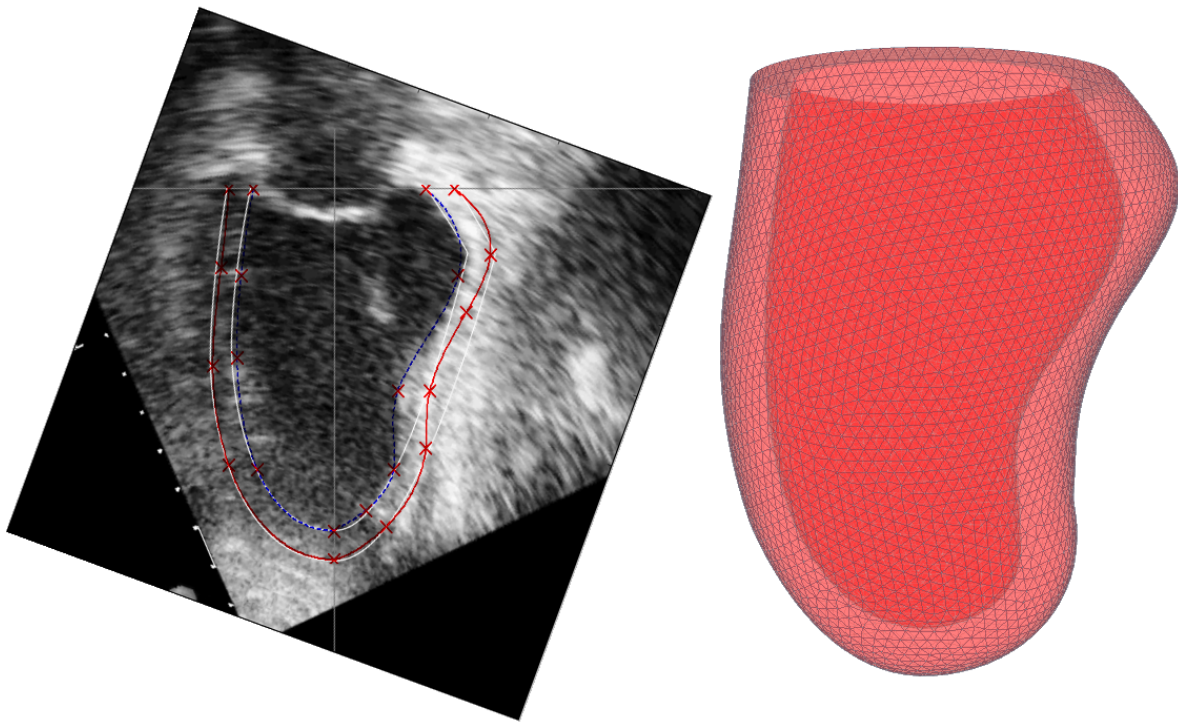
Ultrasound imaging as a base for model construction. *On the left:* a sonographical two-chamber view of a patient's heart and two measurements: the first for the power-function-based model (white lines) and the second for the spline-based model (blue lines show the endocardium; red lines show the epicardium). The patient suffered from an old myocardial infarction, and a scar is present. The marked points are shown as crosses. This view gives data for two model meridians. The model axis and base are shown as grey lines. The image has been rotated so that the model axis Oz is vertical. *On the right:* a spline-based model of this patient's LV. The view is semitransparent to show both the epicardial and endocardial surfaces. The surface mesh was made using Ani3D-AFT software [56].
